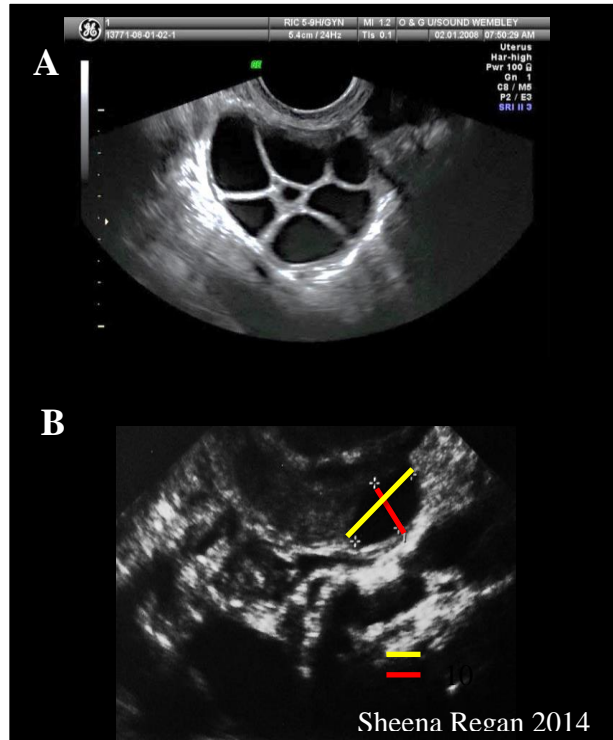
Ultrasound measurement of human follicles.*
